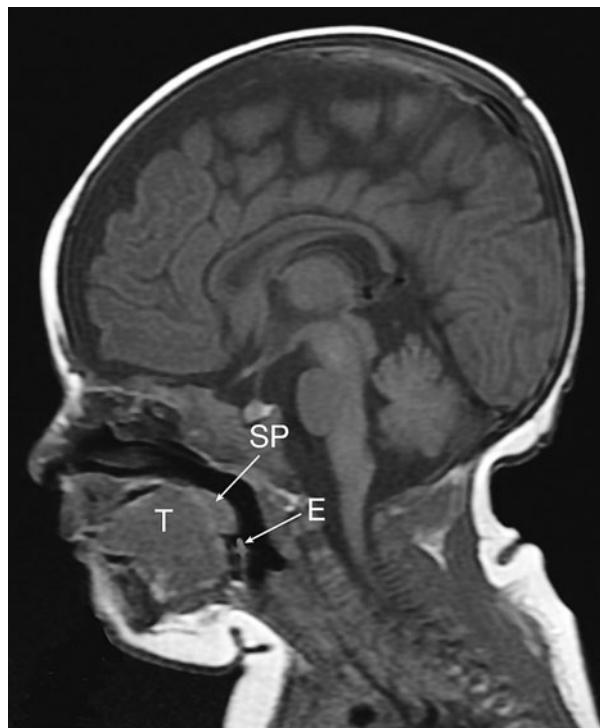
Sagittal magnetic resonance image of the upper airway in a newborn. T = tongue, SP = soft palate, E = epiglottis. Courtesy of Professor Terry Doyle.
